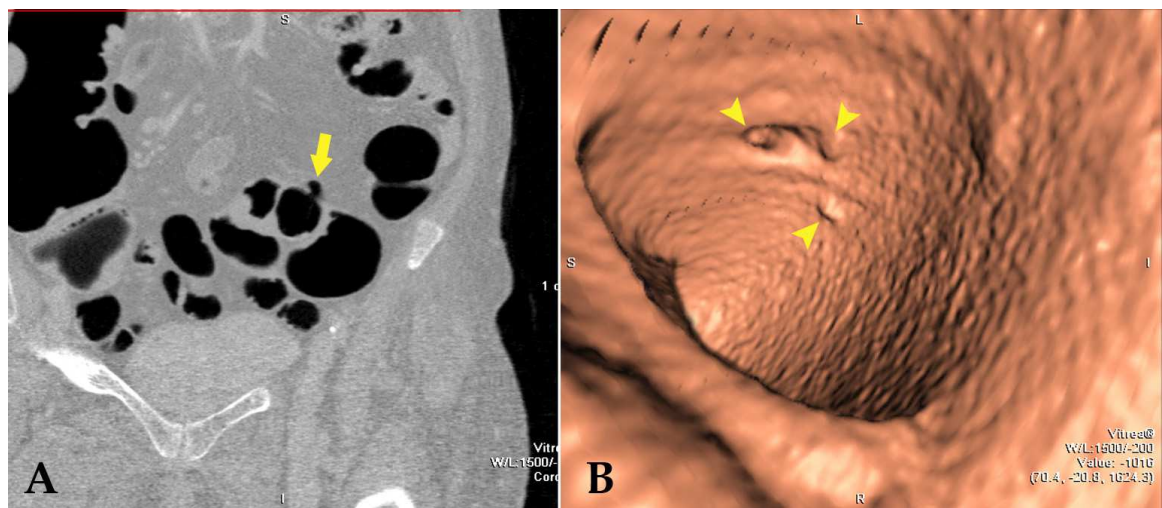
The appearance of diverticula on (A) the 2D axial CT colonographic image (arrow) and (B) the 3D CT colonographic image (arrowheads).
